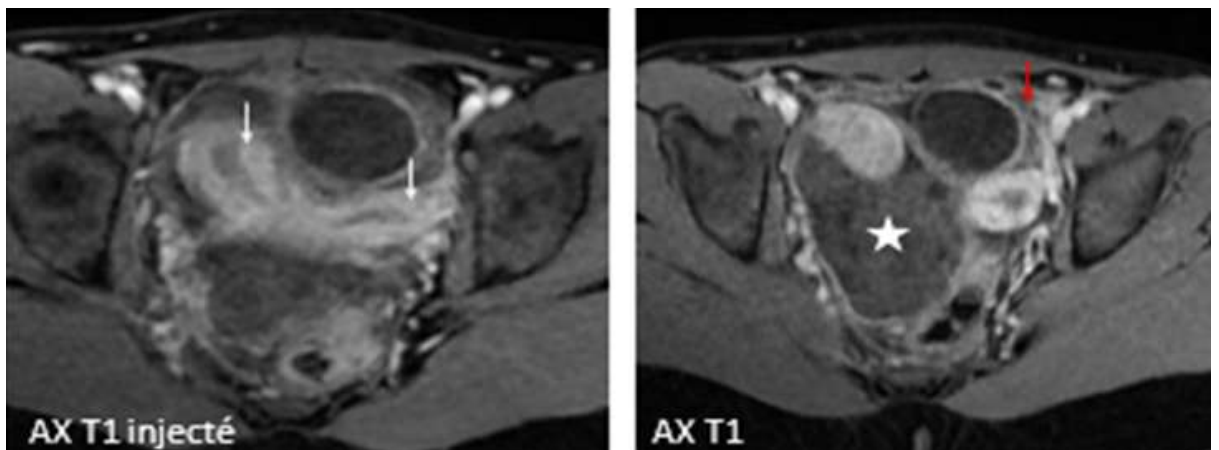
Pelvic MRI showing a bicornuate uterus (white arrow), normal enhancement of the left ovary which is the seat of a cystic lesion (red arrow), and the absence of enhancement of the twisted right ovary (star).
